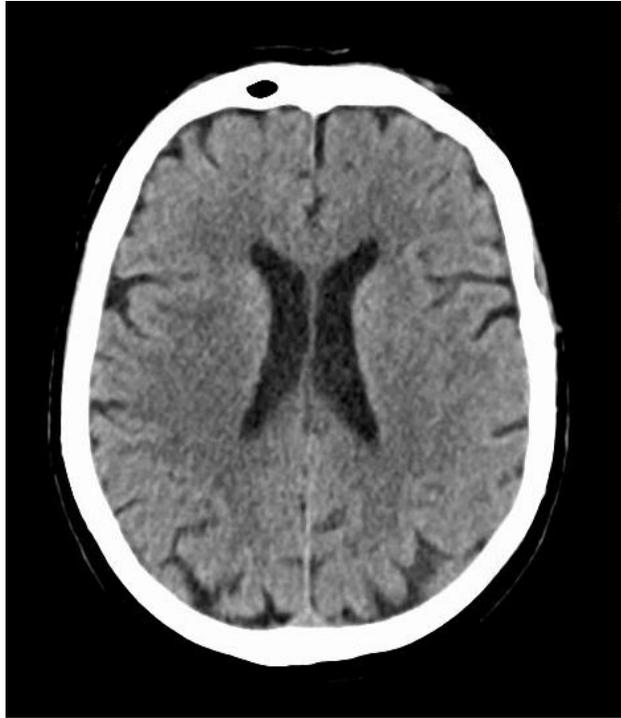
CT scan of head showed acute right MCA infarct.
